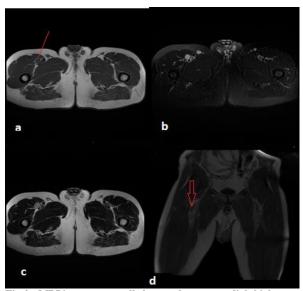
MRI images: a small elongated antero medial thigh mass centered to the nerve root, a: Isosignal on axial T1 weighted sequence, b: Axial T1 FS WS: moderate enhancement after intravenous gadolinium injection, Moderate hypersignal on axial (c) and coronal (d) T2 weighted sequence
